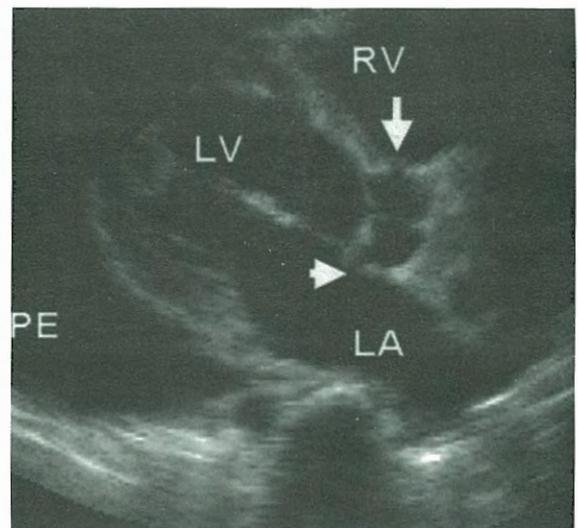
The parasternal long-axis view of the patient reveals the location of the defect between the aorta and the left atrium (arrowhead). A small defect located in the upper portion of the ventricular septum is seen (arrow). Left ventricle (LV) is mildly dilated. A large pericardial effusion (PE) is also seen. RV: right ventricle, LA: left atrium.
